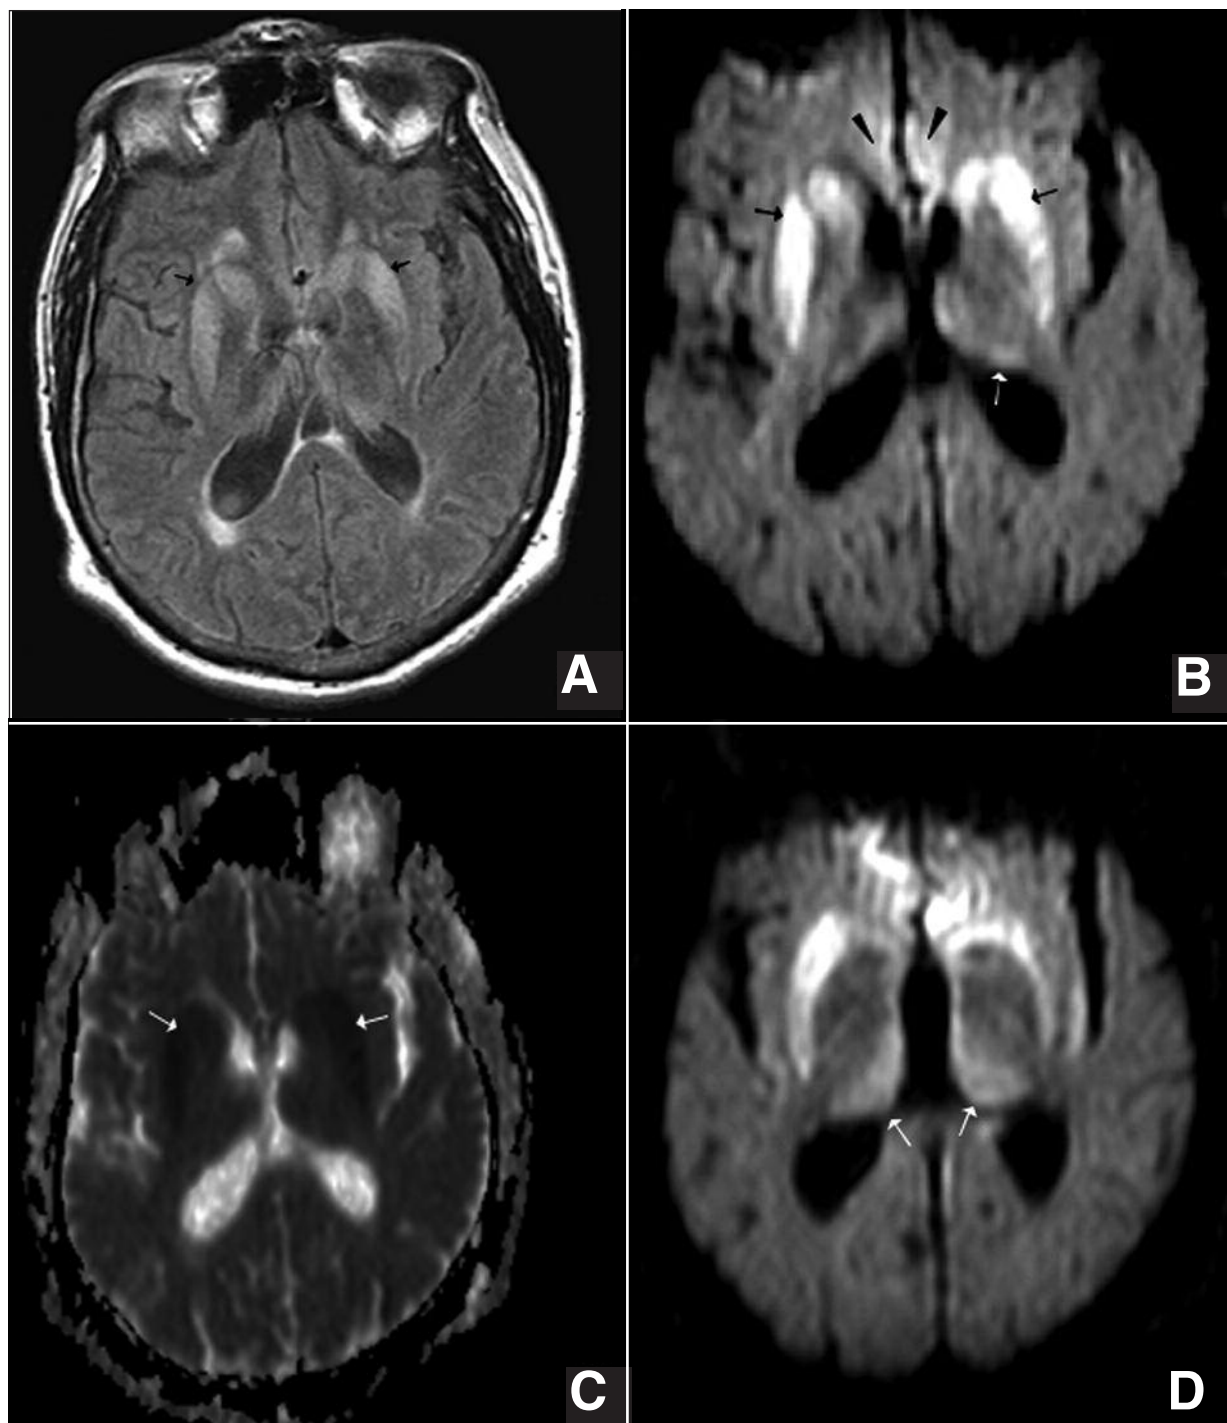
Image A: Bilateral hyperintensities involving the putamen and caudate symmetrically on FLAIR sequence (arrows). Image B: DWI reveals pronounced hyperintensities in the striatum (black arrows) and cingulum bilaterally (arrow heads), and left thalamus (white arrow). Image C: ADC showing reduced signal in the striatum bilaterally corresponding to the DWI signals (white arrows). Image D: DWI showing bilateral "hockey-stick" involvement of the mediodorsal thalami.
